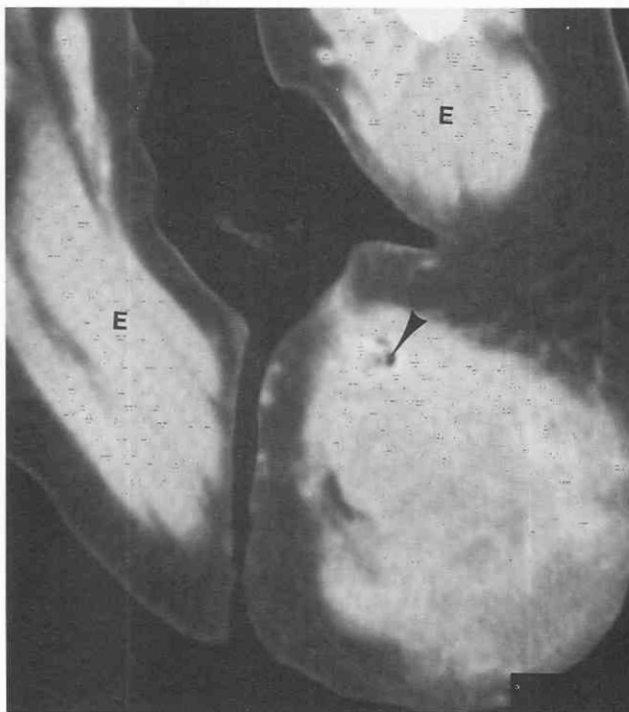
Malignant presacral teratoma in a newborn girl with a gluteal mass. CT scan demonstrates a large heterogeneous mass of soft tissue density displacing the gas-filled rectum (*arrowhead*) anteriorly. *E*, lower extremities.
